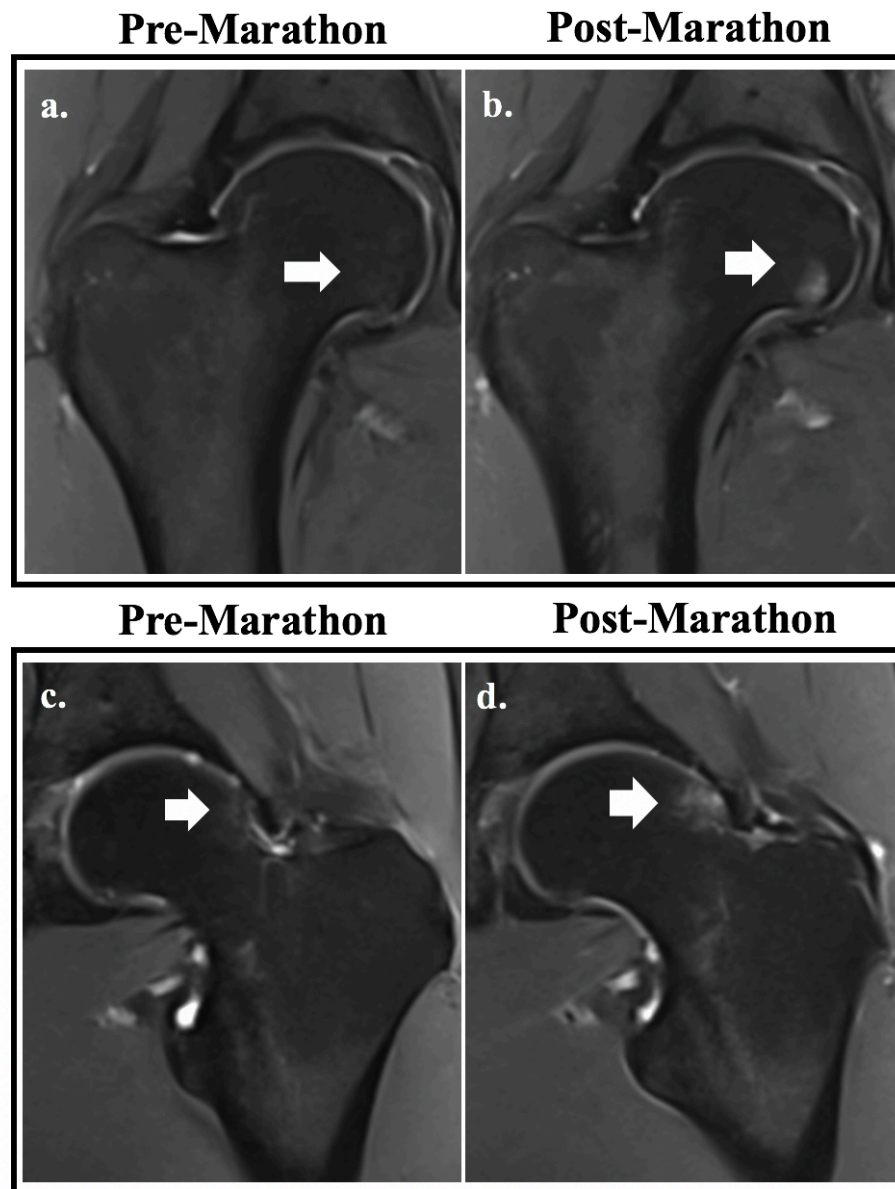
Coronal Dixon MR images of 2 participants showing all subchondral BME changes after the marathon: Participant 1 had no edema before the marathon (a) and mild edema appeared after the marathon (b; grade 2, size between 0.5-1.5 cm); Participant 2 had little edema before the marathon (c; grade 1, <0.5 cm in size) which slightly extended after the marathon (d; grade 2, size between 0.5-1.5 cm). SHOMRI grading system was used; SHOMRI, Scoring hip osteoarthritis with MRI; BME, bone marrow edema.
